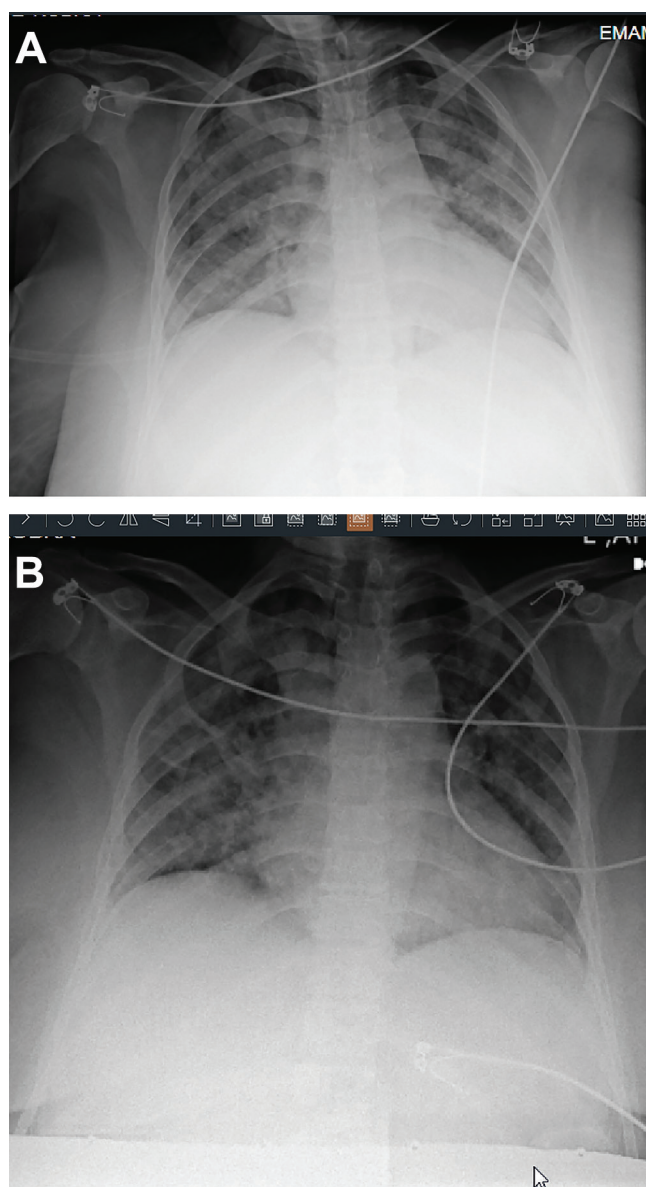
A: Chest X-ray Shows bilateral pulmonary edema, B: decreased edema with intravenous diuretics. White arrow shows abdominal lead shield to decrease fetal radiation exposure.
